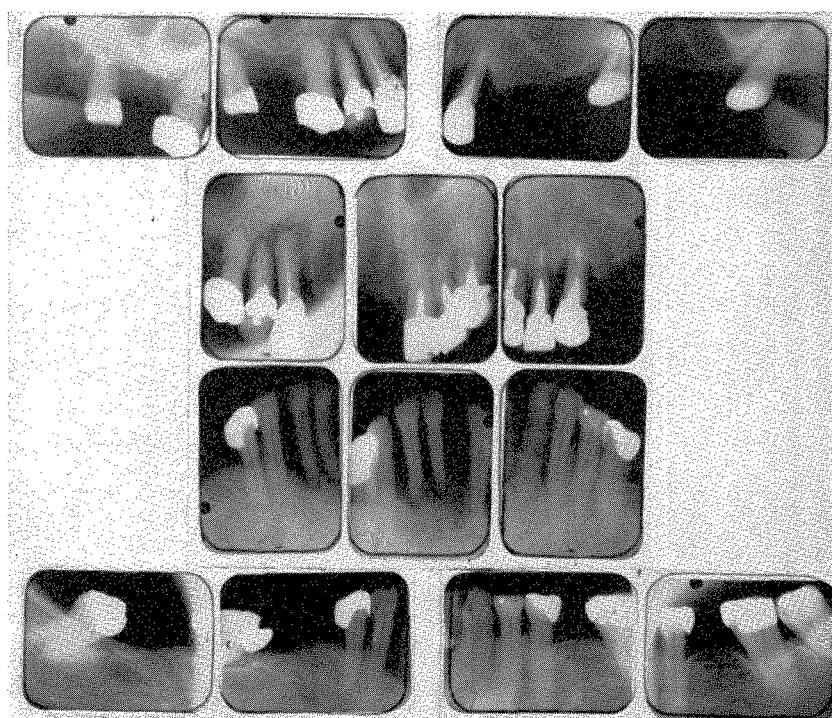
Roentgenograms of the teeth at the start of treatment (1943).
